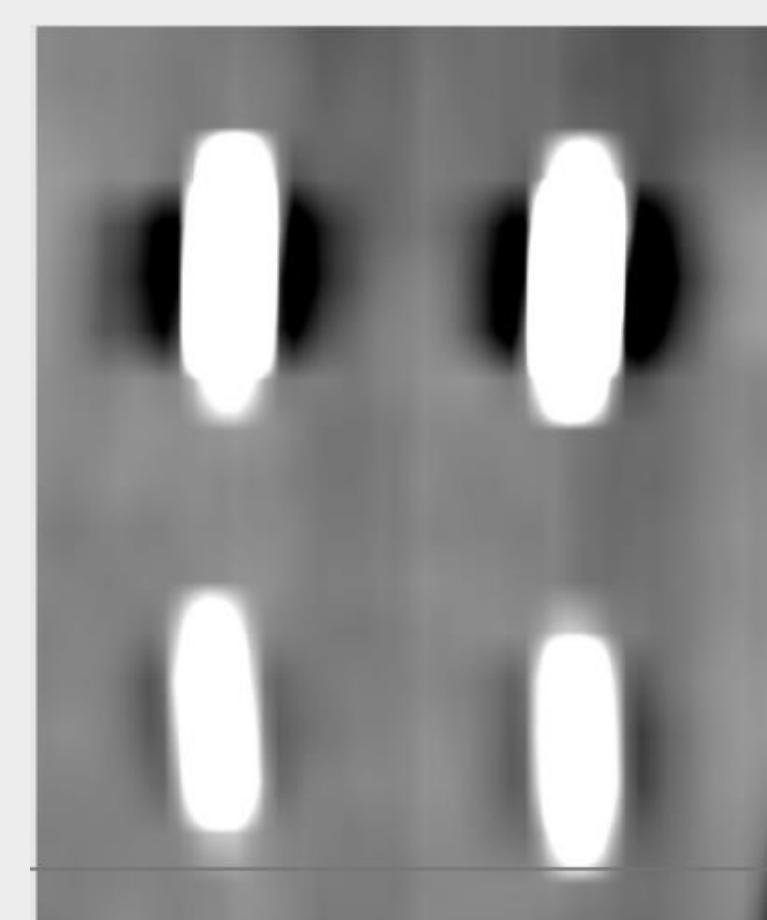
CT image from dataset 1 with gold-marker seeds on top row and no-marker seeds on bottom row
